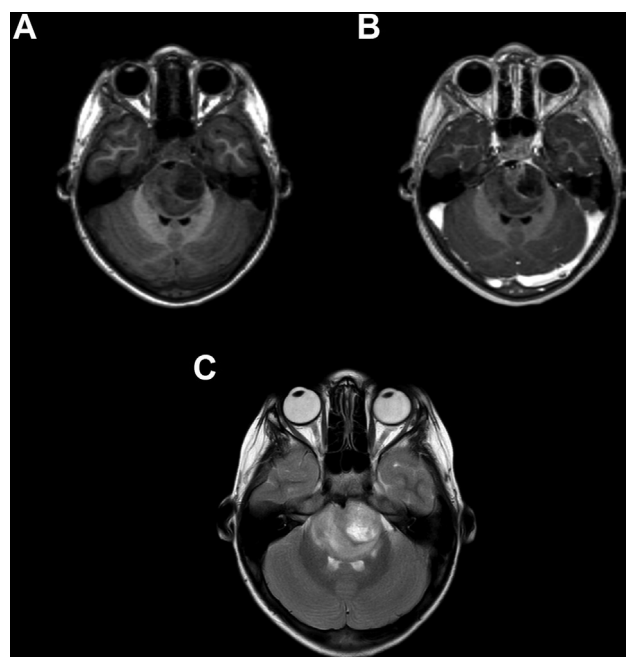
Magnetic resonance imaging (MRI) of pediatric brainstem diffuse midline glioma (DMG)-H3 K27M-altered. (A) T1-weighted MRI. The tumor is hypointense. (B) T1-weighted contrast-enhanced MRI. There is minimal and heterogeneous enhancement. (C) T2-weighted MRI. The tumor is heterogeneously hyperintense.
